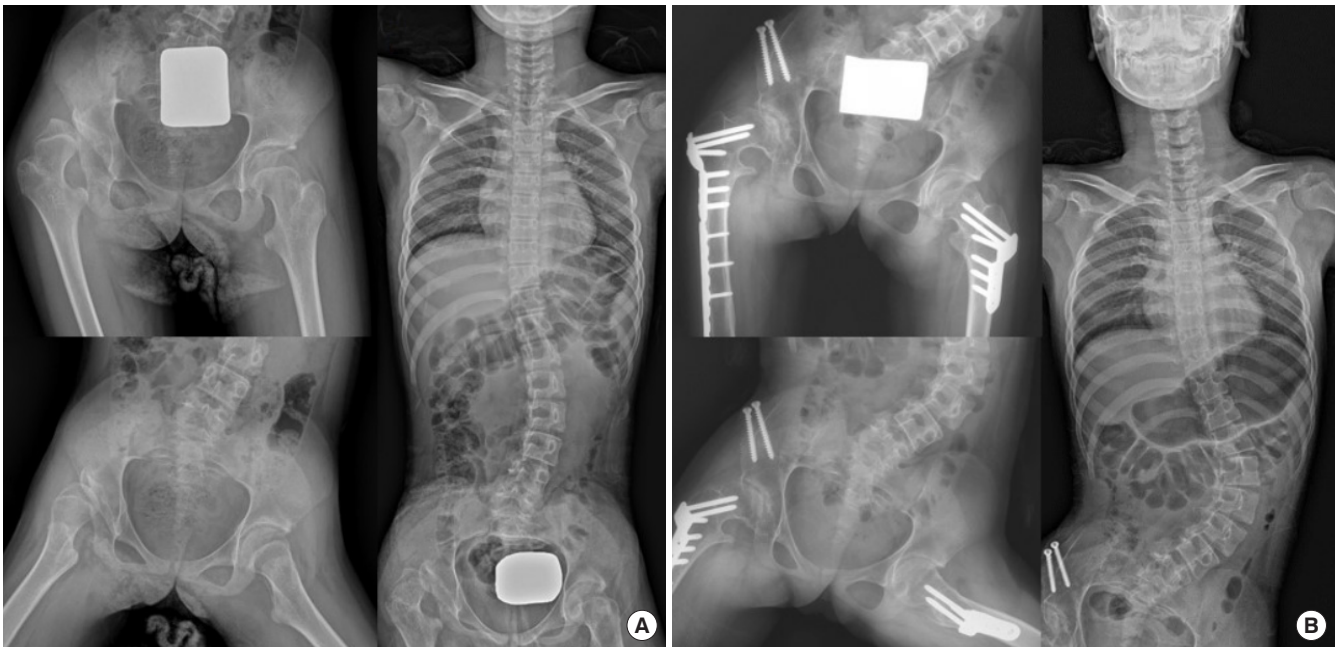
(A) An 11-year-old girl with spastic quadriplegic cerebral palsy had a right hip dislocation and 37° of scoliosis from T11 to L4 in supine radiography. (B) At the postoperative 2-year follow-up after reconstructive surgery for hip dislocation, the reduction of the hip was maintained, but the scoliosis had progressed to 82° from T11 to L4 in supine radiography.
